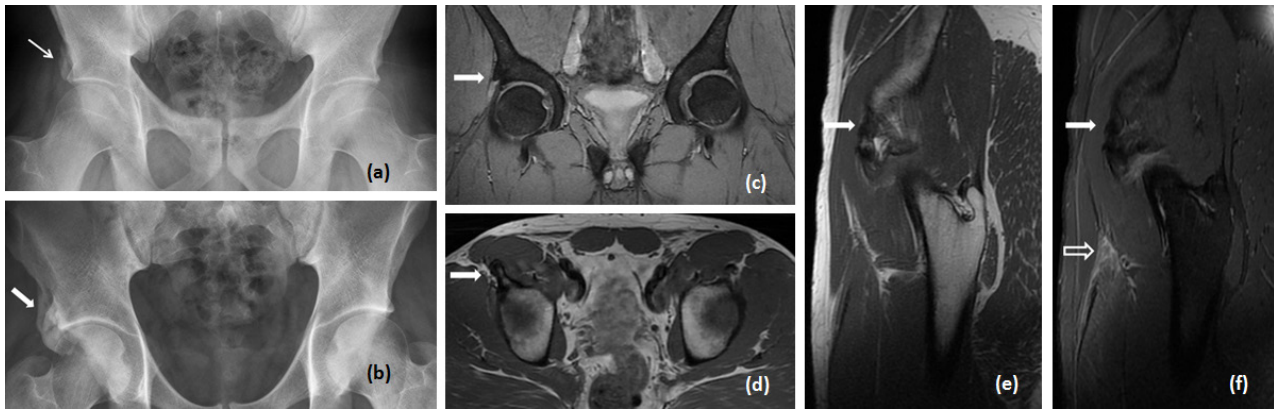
Anteroposterior radiographs of the pelvis from two different patients are shown. Right sided avulsion fracture of the anterior inferior iliac spine (AIIS) (arrow) is shown in the first patient (a), a 29-year-old recreational football player who reported a snapping sound together with a feeling of tearing at his right hip while shooting the ball. The second patient (b) is a 26-year-old professional football player with right sided hypertrophic AIIS (arrow). He was referred for imaging because of right hip pain during the game. His coronal gradient echo (c), axial (d) and sagittal (e) T1-weighted and sagittal fat suppressed PD-weighted (f) MR images are shown. Note that the AIIS on the right hip is substantially hypertrophic (arrows). Sagittal fs- PD image in (f) depicts a recent proximal rectus femoris muscle strain (open arrow).
